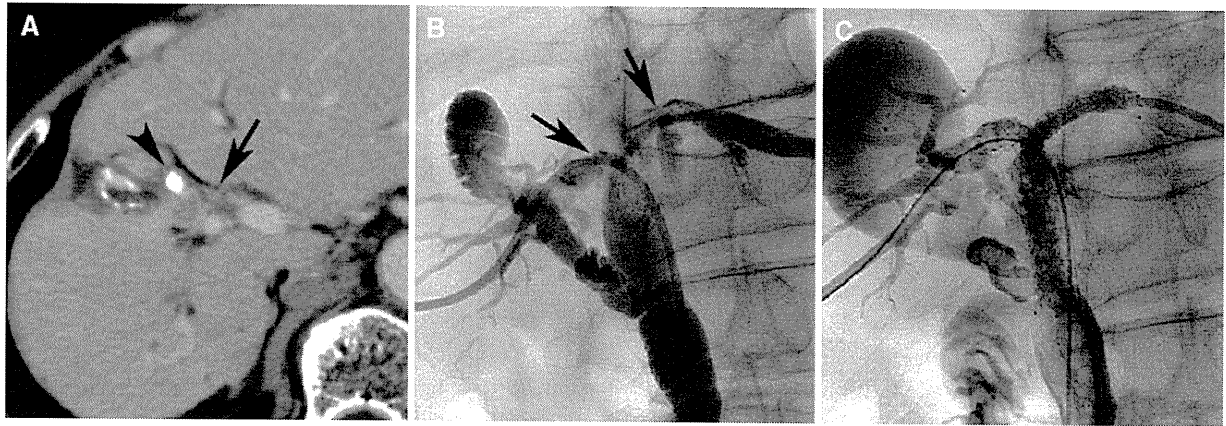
A 68-year-old man with bile duct strictures at the hepatic hilum (patient no. 17). A CT obtained before the additional fourth TACE session (at 22 months after demonstration of bile duct dilatation) shows the stricture and wall thickening of the CHD (*arrow*) in addition to intrahepatic bile duct dilatation. The *arrowhead*
